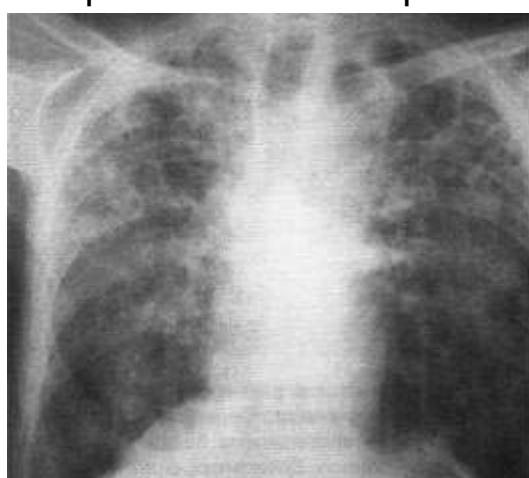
Chest radiograph of patient S., 43 years old, frontal projection.
